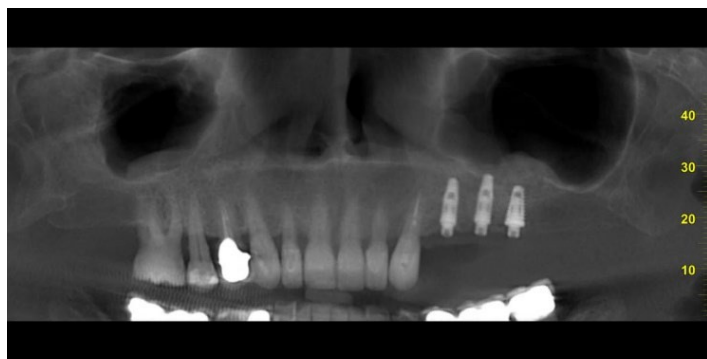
Final X-ray check
